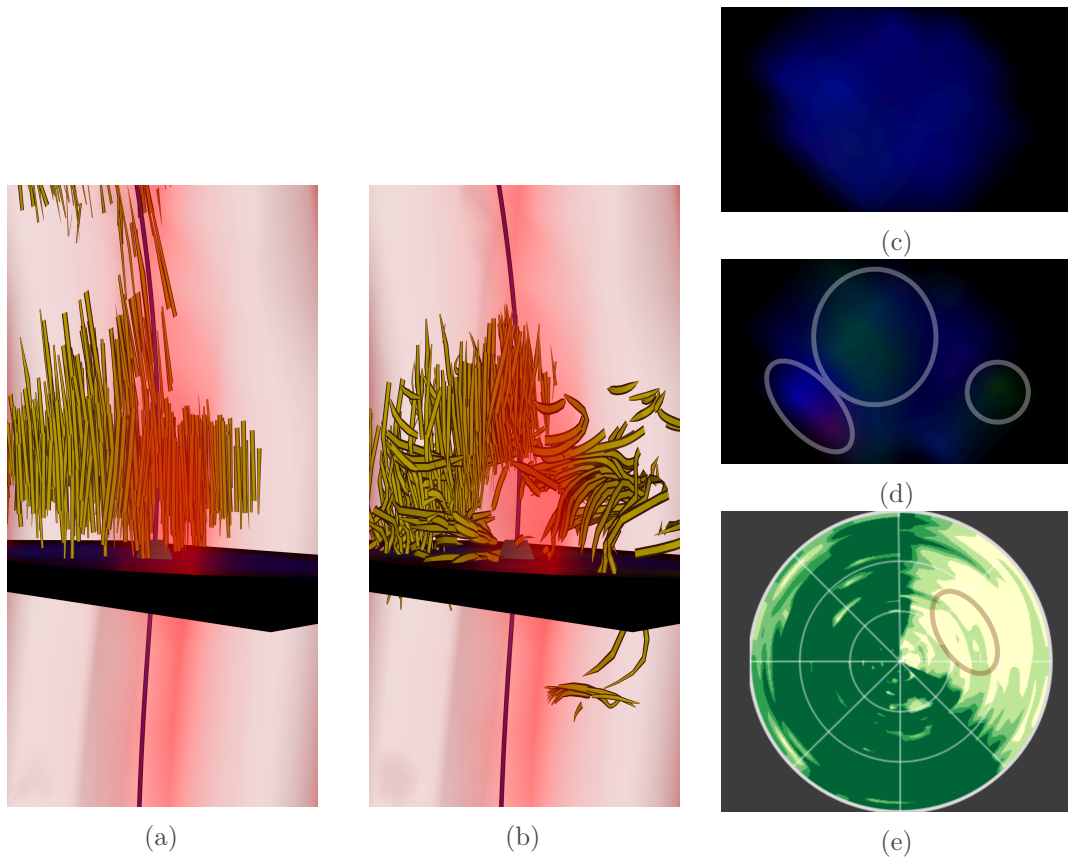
Changes in flow representation (a,b) and average flow angle bull's eye plot (e) due to deviations in the flow field (c,d) as a result of different MRI sequences.
